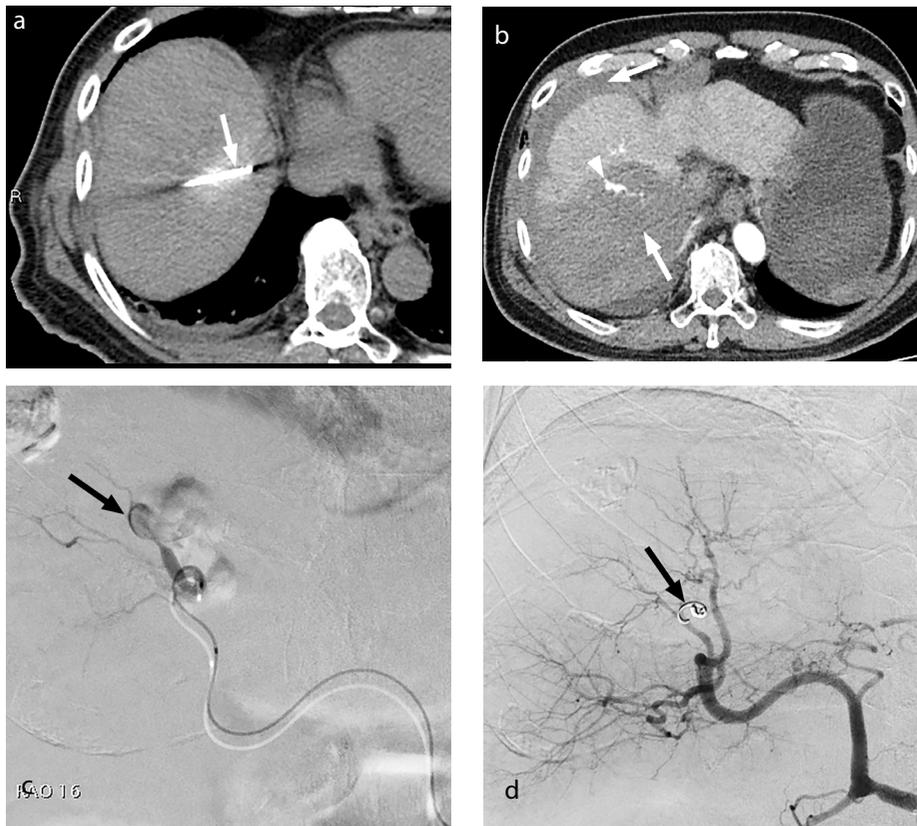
(a-d) Ruptured hepatic artery pseudoaneurysm with delayed presentation after radiofrequency ablation (RFA) of a segment 7 hepatocellular carcinoma. Axial plain computed tomography image (a) shows the final position of the RFA needle (arrow) before ablation. Axial contrast-enhanced computed tomography (six days post ablation) image (b) in the arterial phase demonstrates large intrahepatic and perihepatic hematomas (arrows) with a focus on active contrast extravasation (arrowhead). Selective angiogram (c) of the offending branch of the right hepatic artery shows a ruptured pseudoaneurysm (arrow) with active contrast extravasation. Post-embolization angiogram (d) shows successful embolization with 3 mm coils (arrow).
